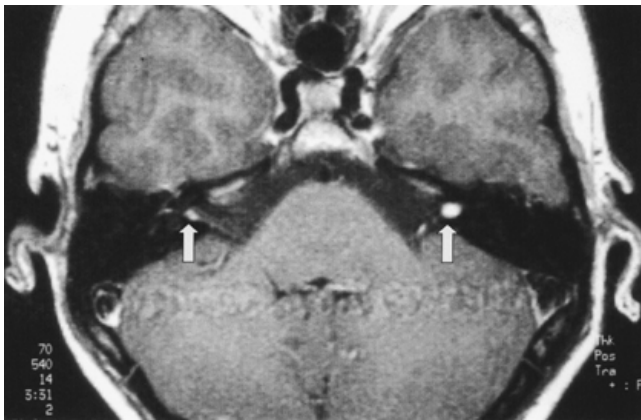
A gadolinium-enhanced magnetic resonance image (MRI) (T1 weighted, axial plane) through the internal auditory canal (IAC) of an asymptomatic 13-year-old patient with a family history of neurofibromatosis type 2 (NF2). This screening MRI shows bilateral enhanced masses within the patient's IACs consistent with the presence of bilateral vestibular schwannomas (arrows) and confirms a diagnosis of NF2.
